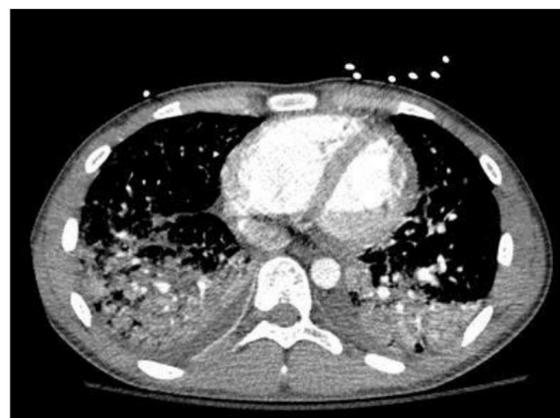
CTA of the chest demonstrating evidence of right ventricular enlargement especially when compared to patients first CT of the chest.
